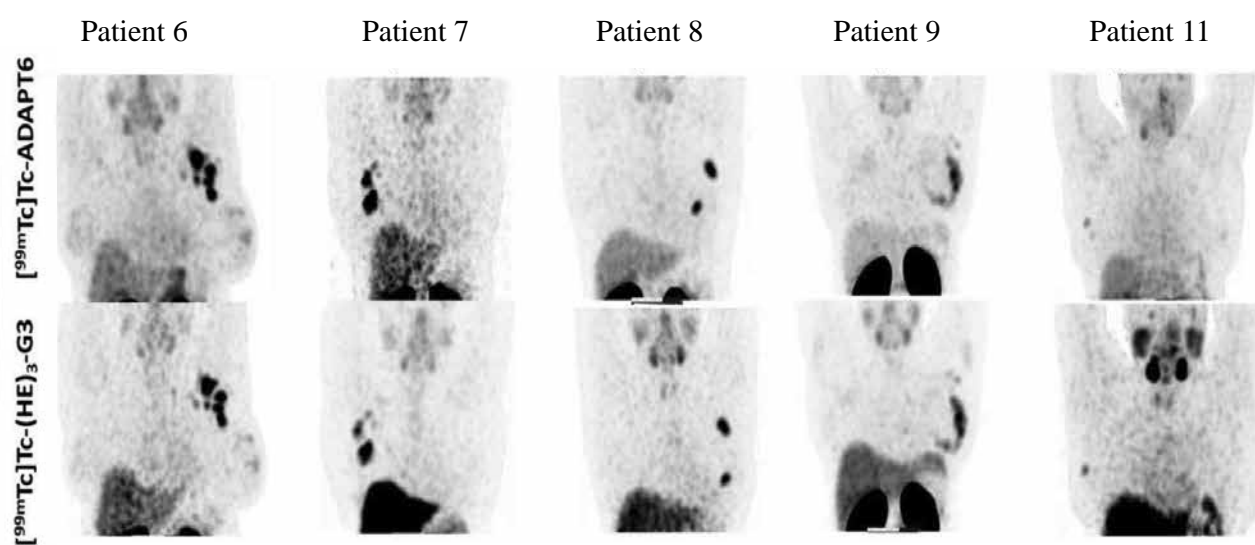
Comparison of SPECT / CT using [ $^{99m}\text{Tc}$ ]Tc-ADAPT6 and [ $^{99m}\text{Tc}$ ]Tc-(HE)3-G3 in patients with HER2-positive breast cancer (SUV is 6.8 in all images)
